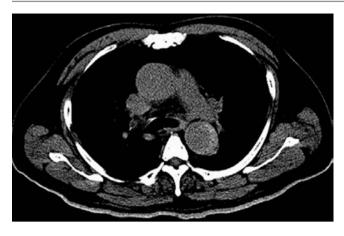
Unenhanced CT with hyperdense appearing acute intramural hematoma
